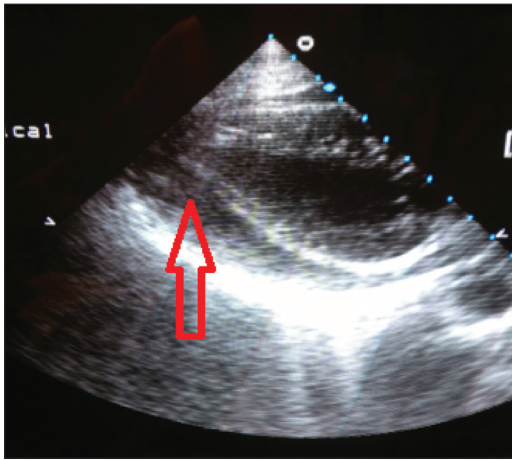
Transthoracic echocardiography showing the pericardial effusion (arrow)
